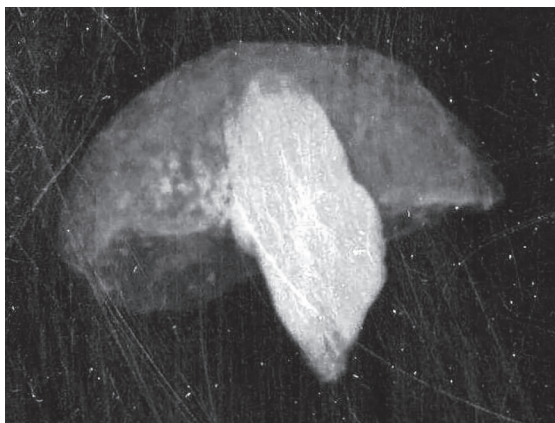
X-ray of the bread loaf from Lovö, where the stone is stuck to the largest lump of the bun. Image: J. Storå, Osteological Research Laboratory, Stockholm University.
